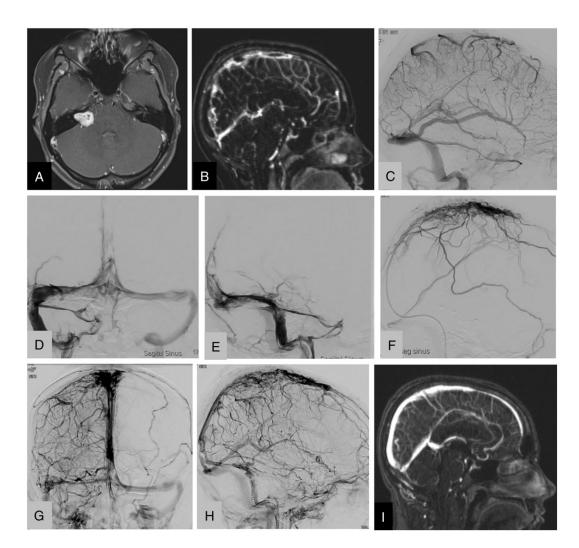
Magnetic resonance imaging (MRI) with gadolinium axial sequence (A) shows a 2 cm contrast-enhancing mass arising from the right internal auditory canal, consistent with a vestibular schwanomma. Magnetic resonance venography (MRV) with gadolinium sagittal sequence (B) and venous phase right internal carotid angiography (C) show occlusion of the superior sagittal sinus. Venous phase posteroanterior (PA) (D) and lateral (E) right common carotid artery (CCA) angiogram after two attempts at mechanical thrombectomy with the 5 Max Reperfusion catheter (Penumbra, Alameda, CA) shows partial recanalization of the posterior sagittal sinus, the right transverse, and right sigmoid sinuses. Interval superior sagittal sinus microinjections lateral view (F) shows opacification of venous channels surrounding a large flow void in the expected area of the superior sagittal sinus, which drain into smaller cortical veins. After 3 thrombectomy passes with the 5 Max catheter, PA (G) and lateral (H) venous phase right CCA angiogram shows significantly improved flow in the superior sagittal, right transverse, and right sigmoid sinuses. Two-week follow-up MRV sagittal sequence (I) shows a patent superior sagittal sinus.
